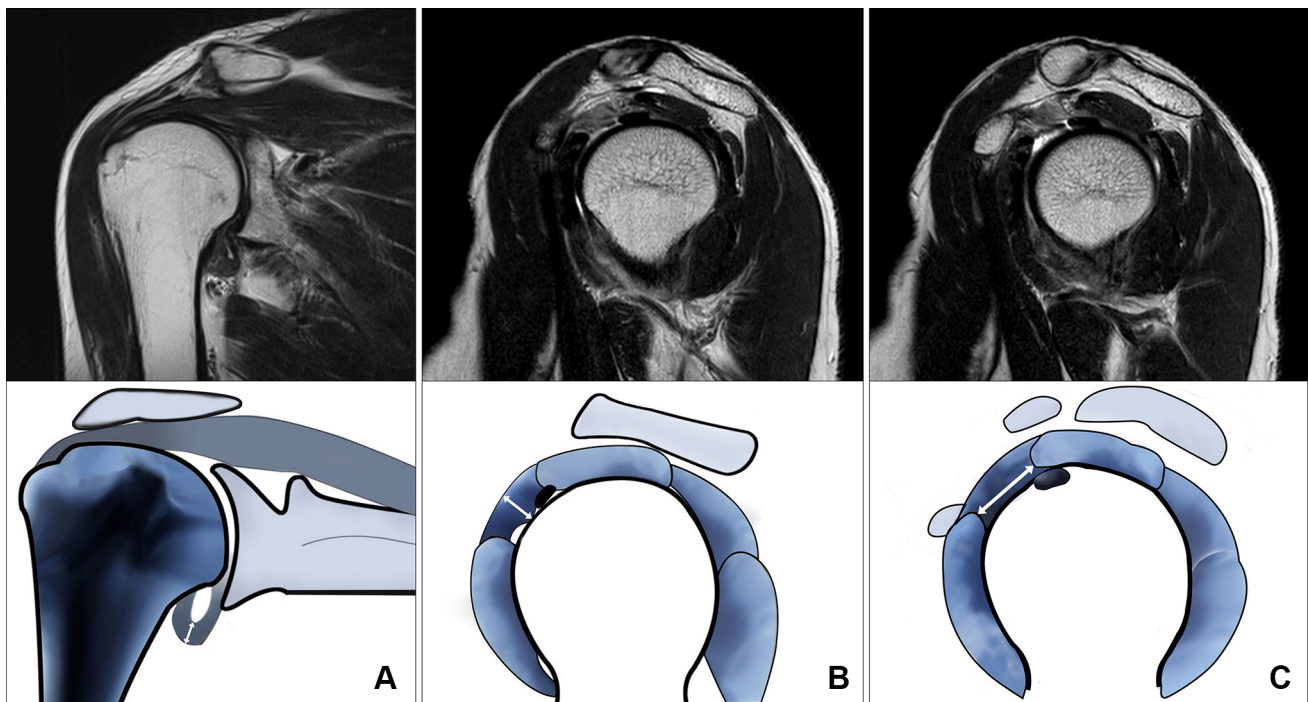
a Capsular thickness in the axillary recess is measured at the thickest portion of the capsule and synovium at its insertion at the humeral head perpendicular to the adjacent cortical bone on coronal oblique T2-weighted images. b Capsular thickness in the rotator interval is measured at the thickest portion of the capsule and synovium between the superior aspect of subscapularis and the anterior
